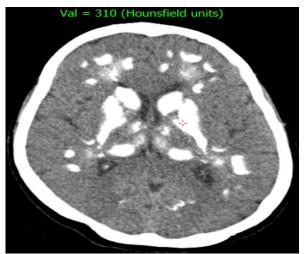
Unenhanced brain computed tomography (CT) scan which shows basal ganglia and subcortical white matter calcification with the Hounsfield level of red cursor area appearing on the top of image
